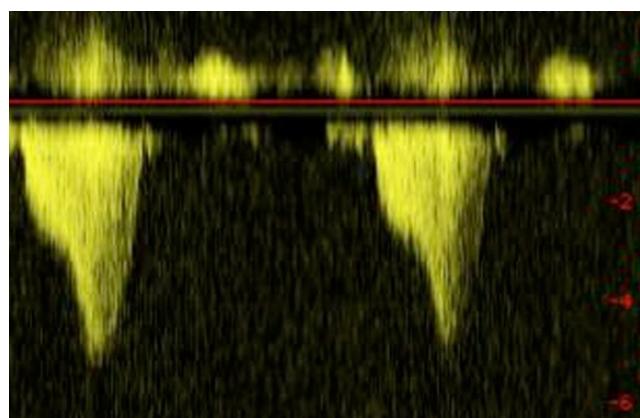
Typical CW-Doppler flow profile of dynamic left ventricular outflow obstruction in HOCM. Note the late-peaking signal indicating to dynamic obstruction involving contracting muscle as opposed to the more symmetrical signal of fixed valvular stenosis. The peak pressure gradient equals $4 \times (\text{peak velocity})^2$
